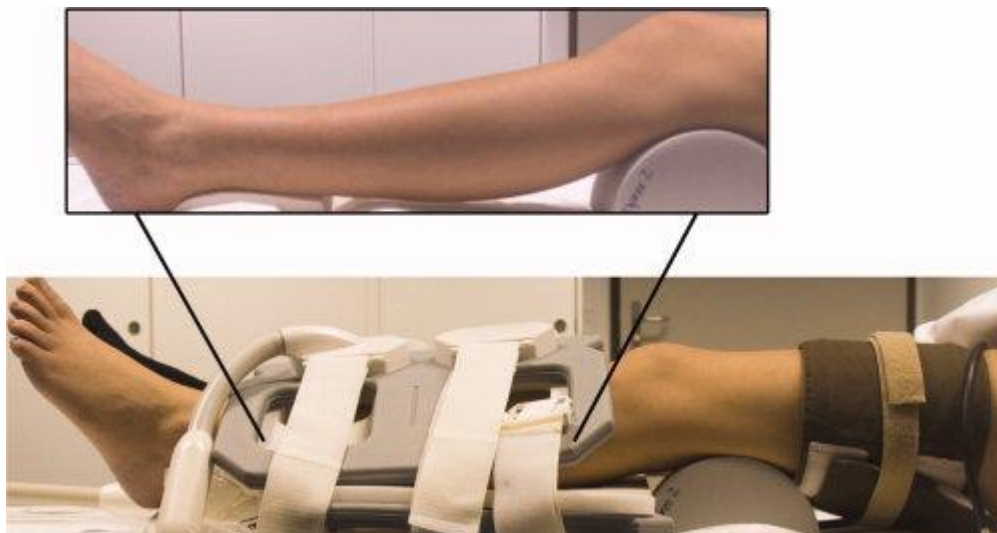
Setup of subjects in the MRI scanner, with thigh cuff in place and 32-channel RF coil placed on the lower leg, centred on the largest part of the calf.
